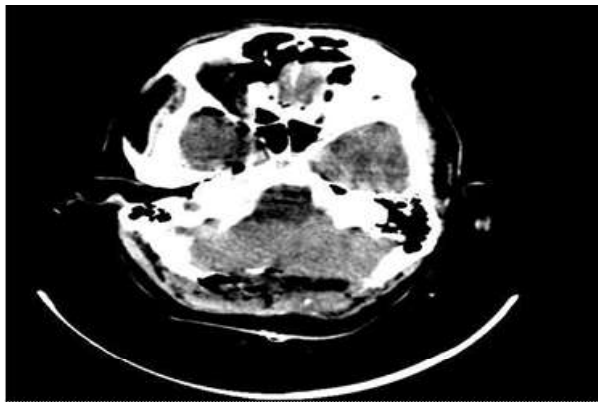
Postoperative CT of Case 1
